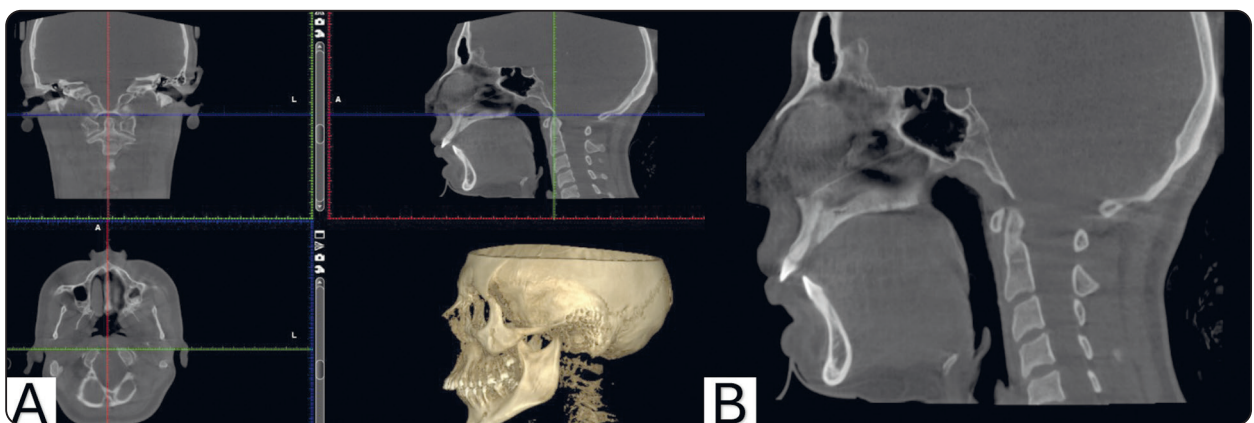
CBCT images showing the adjustment of the scan for cervical vertebrae maturation: (A) CBCT images showing the adjustment of mid-sagittal sections that were used for identification and classification of the cervical vertebrae maturation stages. (B) Sagittal image showing cervical vertebrae maturation stage (CS4) according to *Bacette et al., 2005*⁽⁸⁾; as concavities can be clearly noticed at the lower borders of C2, C3, and C4 with the bodies of C3 and C4 being horizontally rectangular in shape.
